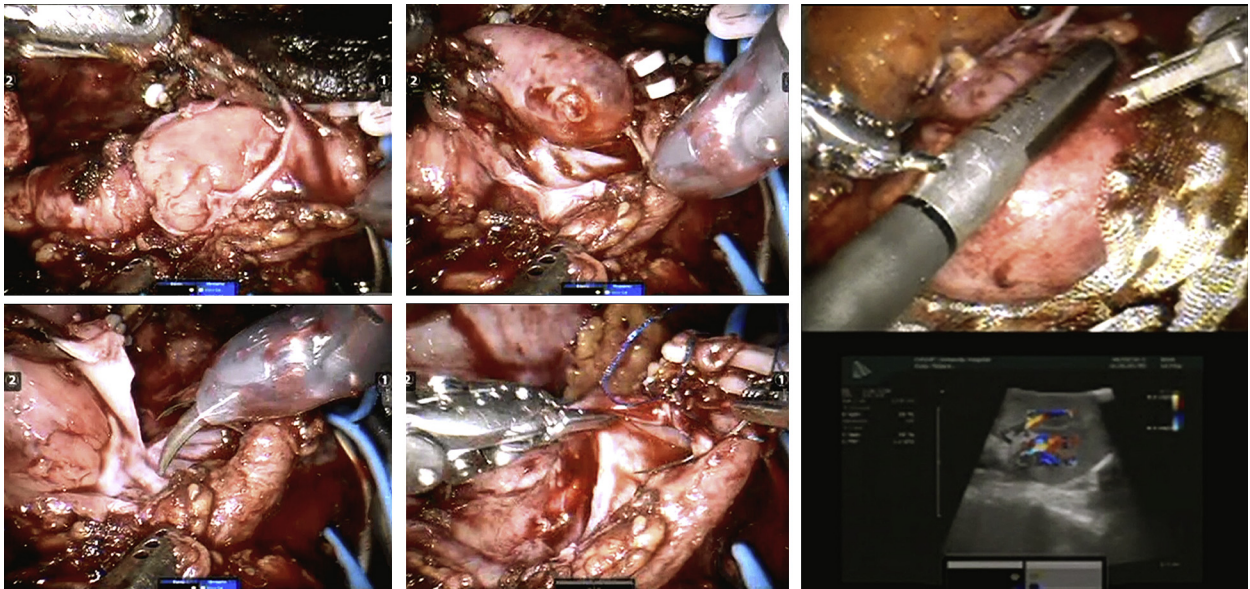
Intraoperative images of tumor thrombus in main renal vein, including incision in renal vein (upper left) to allow extraction of tumor thrombus intact (upper middle), excision of upper pole vein branch containing thrombus (lower left) to allow reconstruction of main renal vein (lower center), and Doppler ultrasound confirming vascular in and outflow in renal remnant (far right). (Color version available online.)
